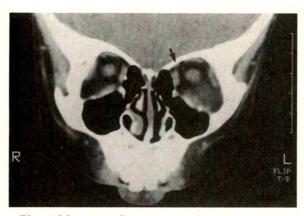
(Matsuo and associates). Case 2. Computed tomography of the orbit showing absence of right superior oblique muscle in coronal section posterior to the globe. Note left superior oblique muscle (arrow).
